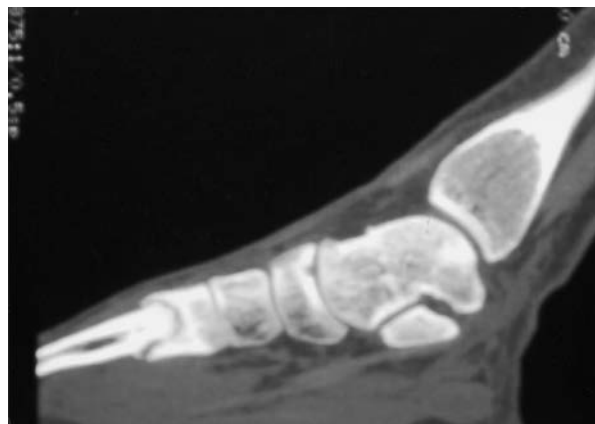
A sagittal computed tomogram (CT) shows a chronic stress fracture of the base of the second metatarsal.
